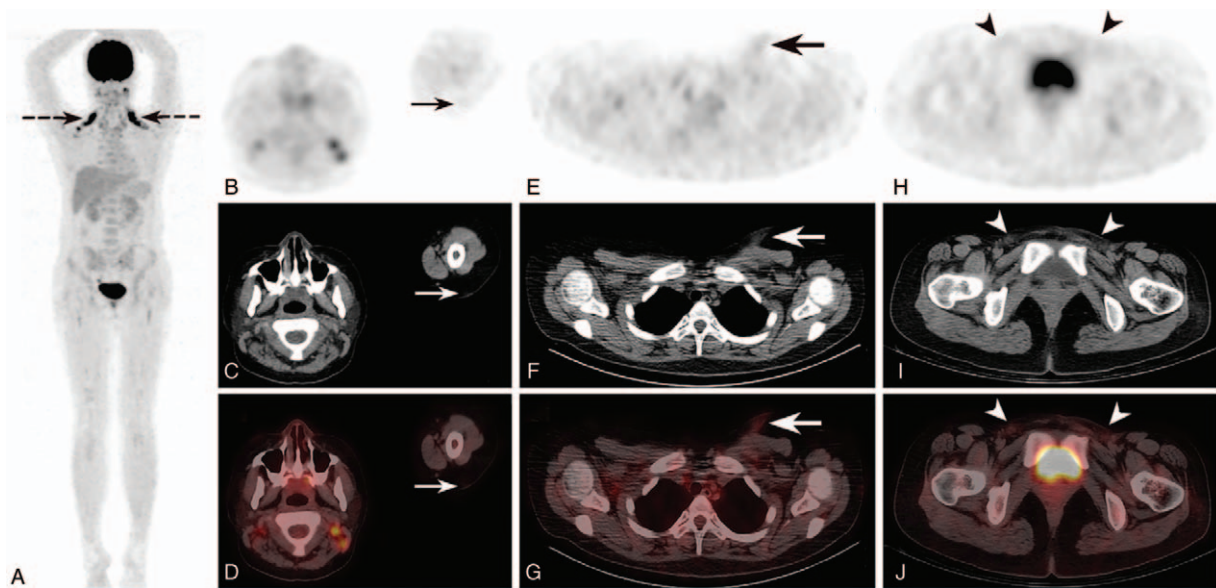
^{18}F -FDG PET/CT images after CHOP treatment of relapsed subcutaneous panniculitis-like T cell lymphoma. A complete remission was observed on interim-FDG PET/CT scan [(A) MIP; (B, E, H) PET; (C, F, I) CT; (D, G, J) fusion] after 3 cycles of CHOP treatment, only with probable inflammatory ^{18}F -FDG activity postchemotherapy on the left chest lesion [(E–G) thick arrows, SUVmax of 1.68] without abnormal uptake in other initially involved sites [(A–D, H–J) thin arrows and arrows]. Extensive cervical brown fat was noted [(A) dotted arrows]. ^{18}F -FDG = ^{18}F -fluoro-2-deoxy-D-glucose, MIP = maximal intensity projection, PET/CT = positron emission tomography/computed tomography.
